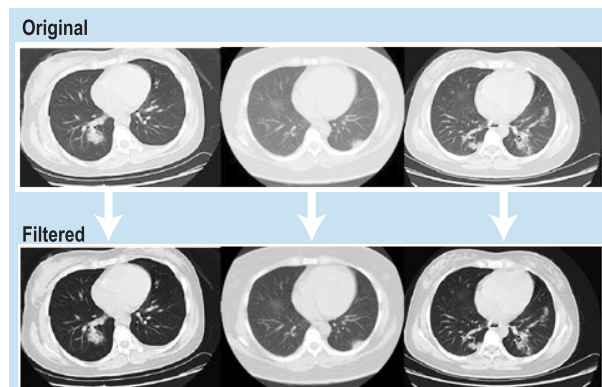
Original and wiener filtered images of lung CT images.
